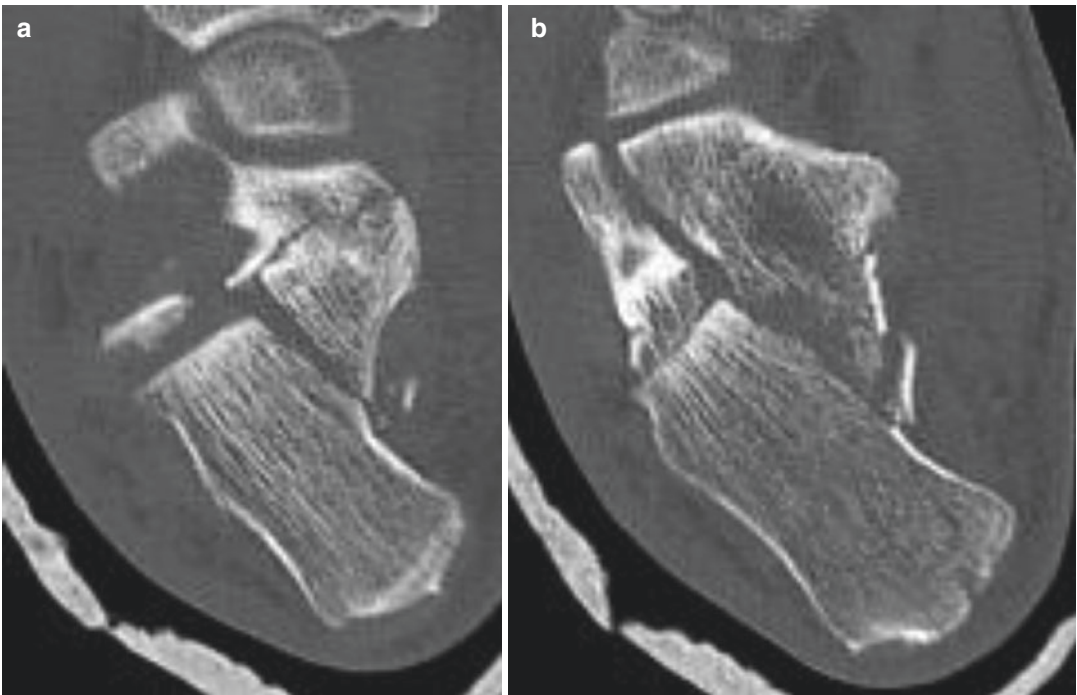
Axial CT images
